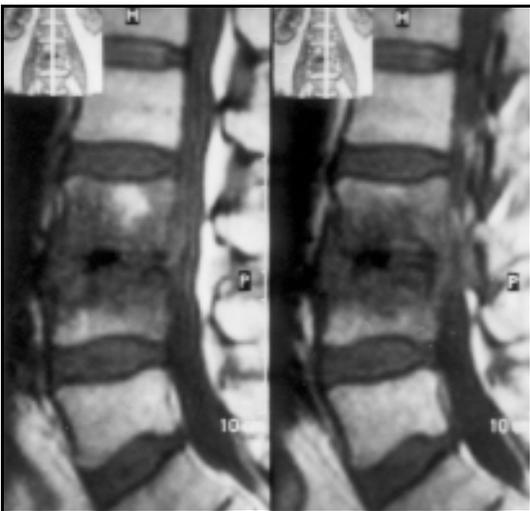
Sagittal T1 weighted MR images show low signal intensity of the narrowing of the third and fourth lumbar vertebral bodies. Intervertebral disc and end plates were destroyed.
